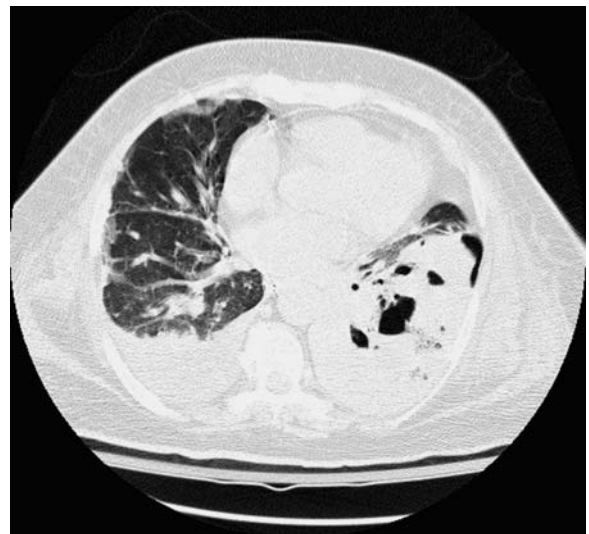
Streptococcal pneumonia in a 61-year-old woman. Chest CT scan (collimation 4×1.25 mm) shows consolidation of left lower lobe with associated areas of cavitation
